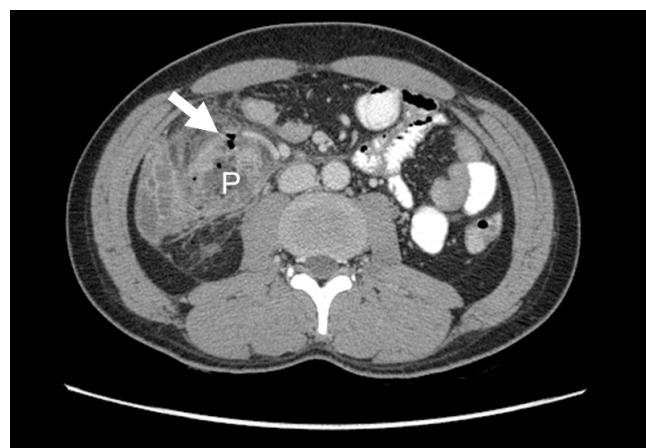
Axial enhanced CT scan of patient with perforated appendicitis, showed pericecal phlegmon (P), showing marked pericecal fat inflammation with ill-defined fluid collection. Extraluminal air bubbles were present (white arrow).
